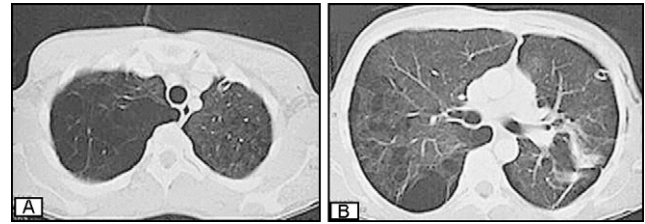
(A, B) Chest CT-scan showing bilateral peripheral bullous emphysema. The pleural drain is in situ on the left side.
